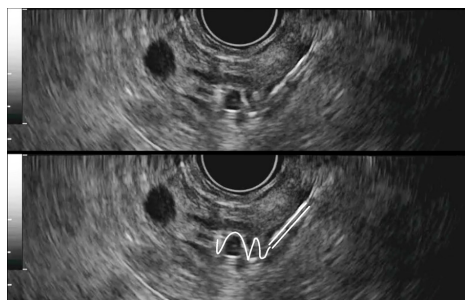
Coil deployment under endoscopic ultrasound guidance, with annotated image showing location of the needle (parallel lines) and coil (single line) within the vessel.
